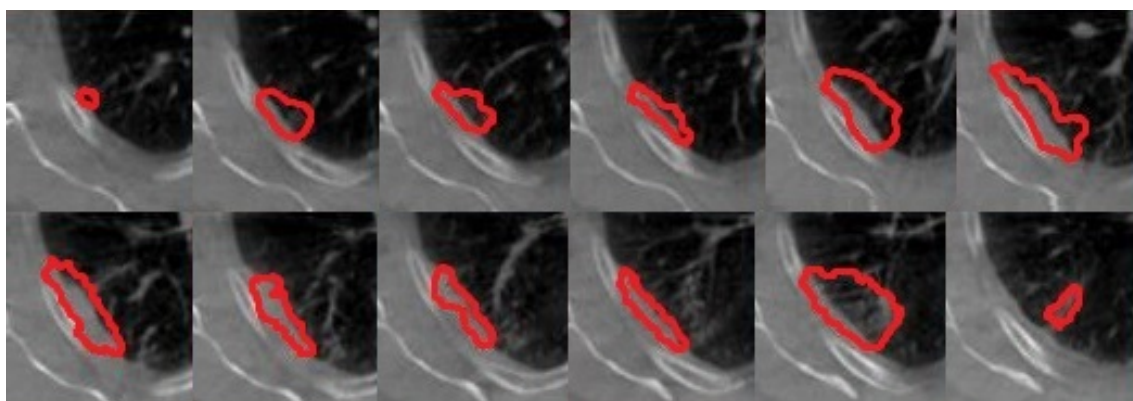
The proposed Model o on CBCT#10 Patient 25, where the red contour is the CT's GTV and the blue contour is the result of level set.
